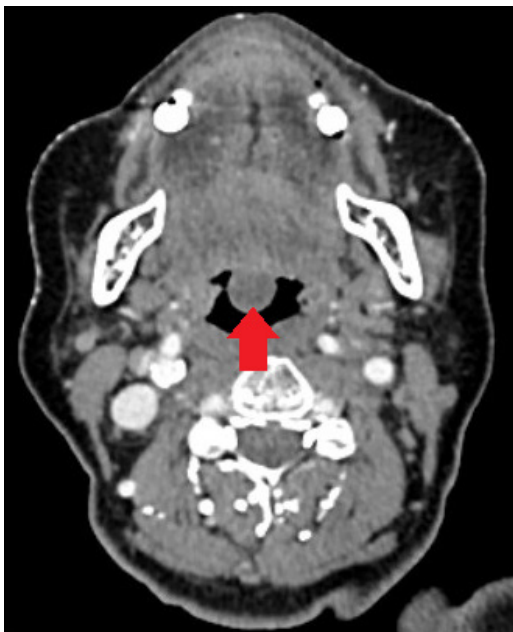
CT scan neck revealing the uvula mass (red arrow) showing the well-defined non-enhancing hypodense lesion in the uvula.
